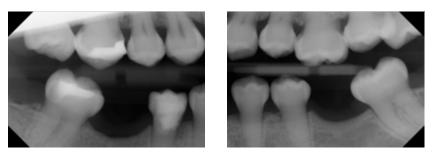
/b Bitewing images after the initial treatment of the patient. Along with radiopacity due to coronal restorations, the bulbous crown shape and extensive obliteration of the pulp chambers were noticeable. No carious lesions were detected. The dentin structures were homogeneous.
